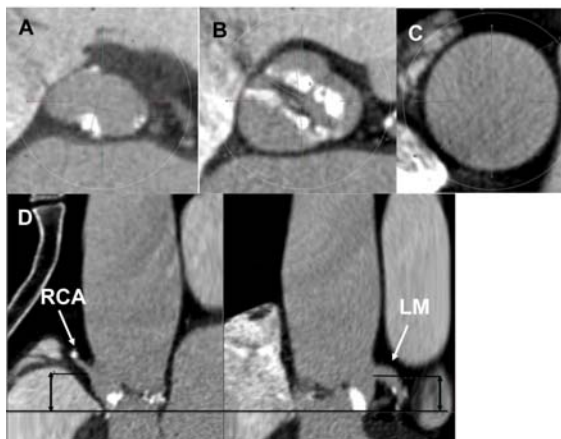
Computed tomography examination: A) Diameters of the aortic annulus; B) Diameters of the sinus Valsalva; C) Diameters of the ascending aorta; D) Distance from the annulus to orifice of the left main (LM) and right coronary artery (RCA).
